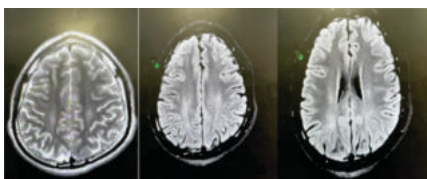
T2/FLAIR Hyperintensities in bilateral Centrum semiovale and corona radiata
